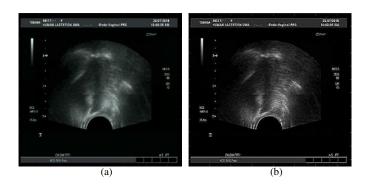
Original ultrasound image from Infant# 6 (a), Enhanced ultrasound image from Infant # 6 (b)
